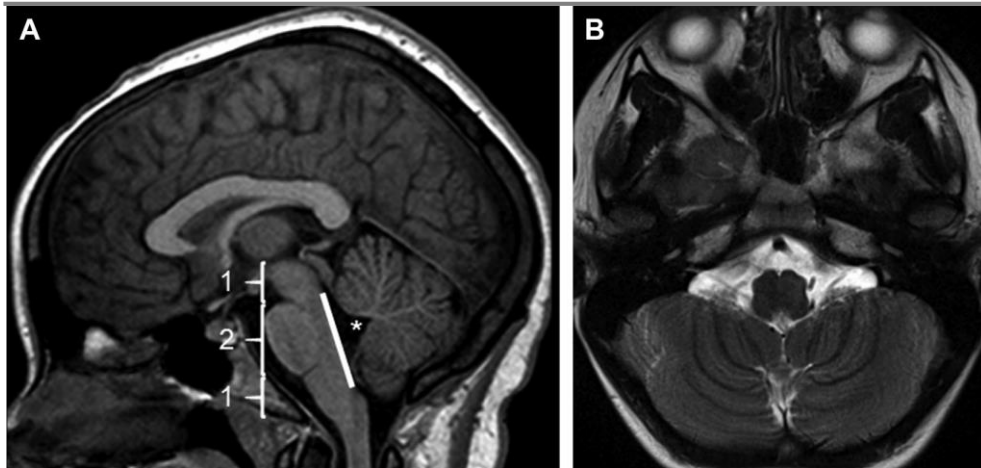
Normal anatomy of cerebellum and brainstem. (A) MRI showing the right proportions of the brainstem: rostrocaudal length of the pons is approximately twice [2] with respect to the midbrain [1] and medulla [1]), the white line indicates a flat dorsal surface of the brainstem, while the asterisk shows the normal position of the fastigium, below the midpoint of the ventral pons. (B) MRI showing the normal orientation of the cerebellar folia (onionlike orientation) (Poretti et al. 2016).
